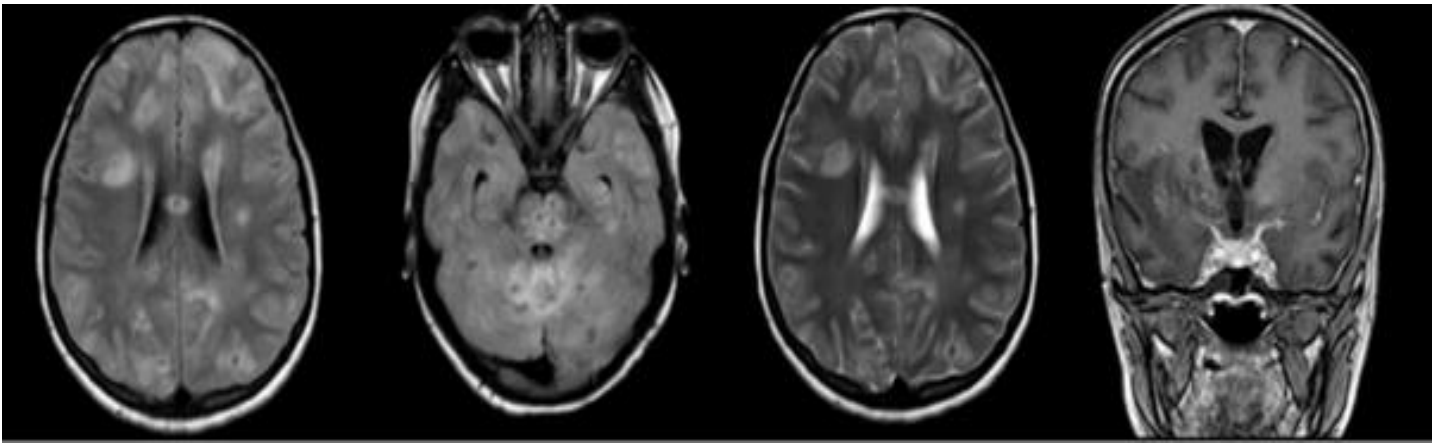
Multiple FLAIR hyperintense contrast enhancing foci noted in the subcortical regions of bilateral frontal, parietal, temporal, occipital lobes, pons and bilateral cerebellar hemispheres. Intense Leptomeningeal enhancement is also seen in the post contrast image.
